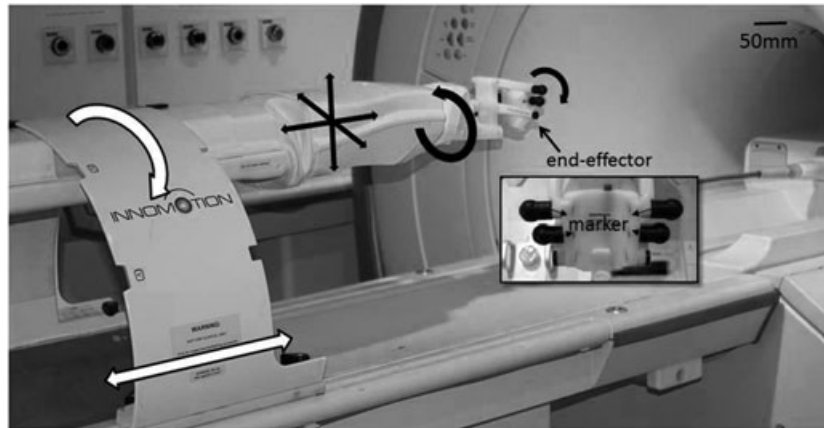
Photo of the robotic arm in front of a 1.5 T MRI scanner, the robot has 5 automate DOF (black arrows) and two manual DOF (white arrows). The enlarged end-effector is with four passive markers filled with Gadolinium contrast agent. Their positions are calculated via processing MR scans through these markers.
